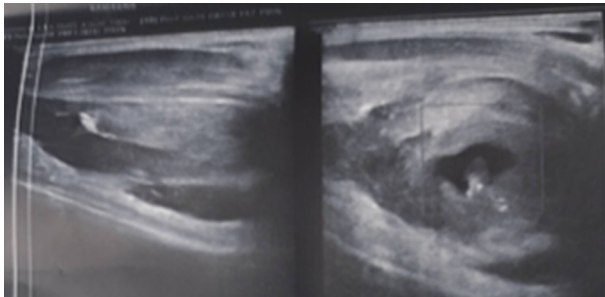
Ultrasound image showing cysticercosis with peripheral collection, edema in adductor pollicis muscles of right hand.
